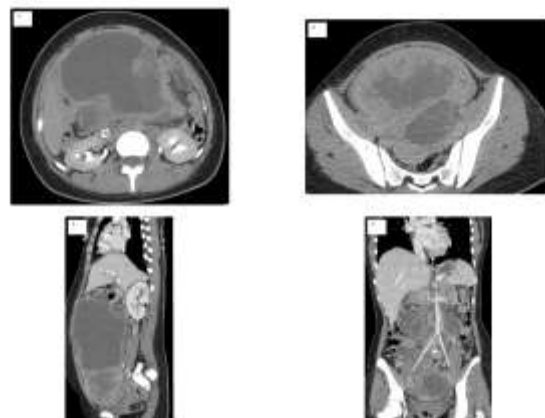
Preoperative computed tomography showing a giant predominantly cystic solid cystic adnexal mass with a heterogeneously enhancing solid component on axial, sagittal and coronal views.
